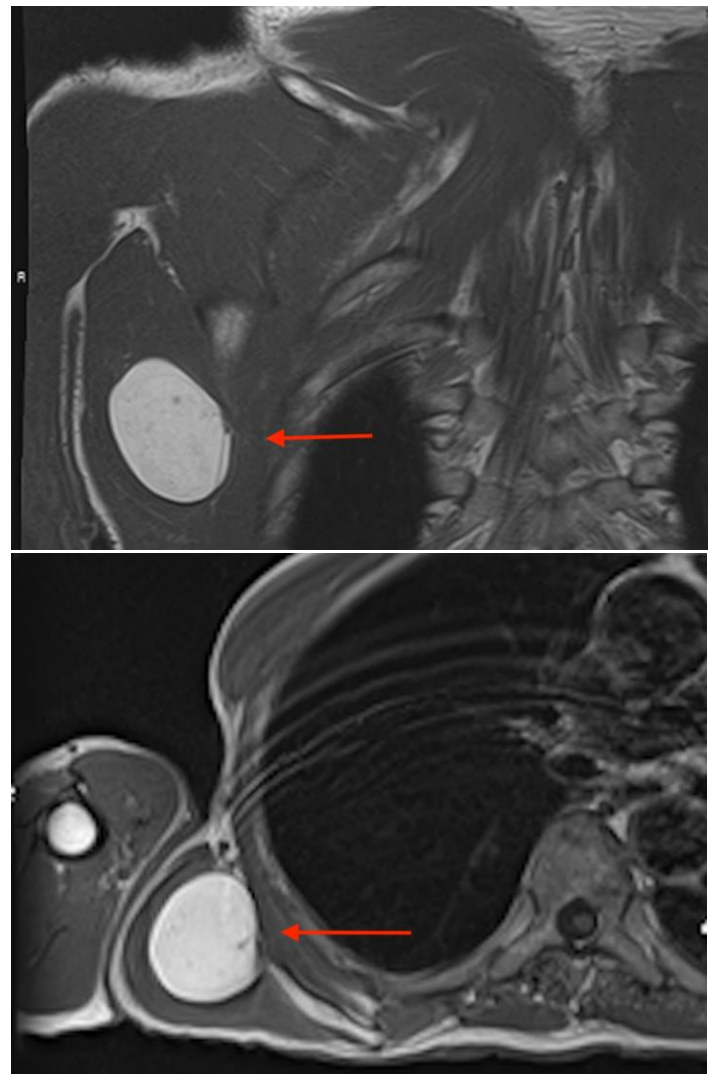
Magnetic resonance imaging of the chest showing an intramuscular fat signal intensity mass lateral to the scapular body within the latissimus dorsi muscle with no internal enhancement, nodularity or adjacent bony destruction in the A) frontal view and B) transverse view.
